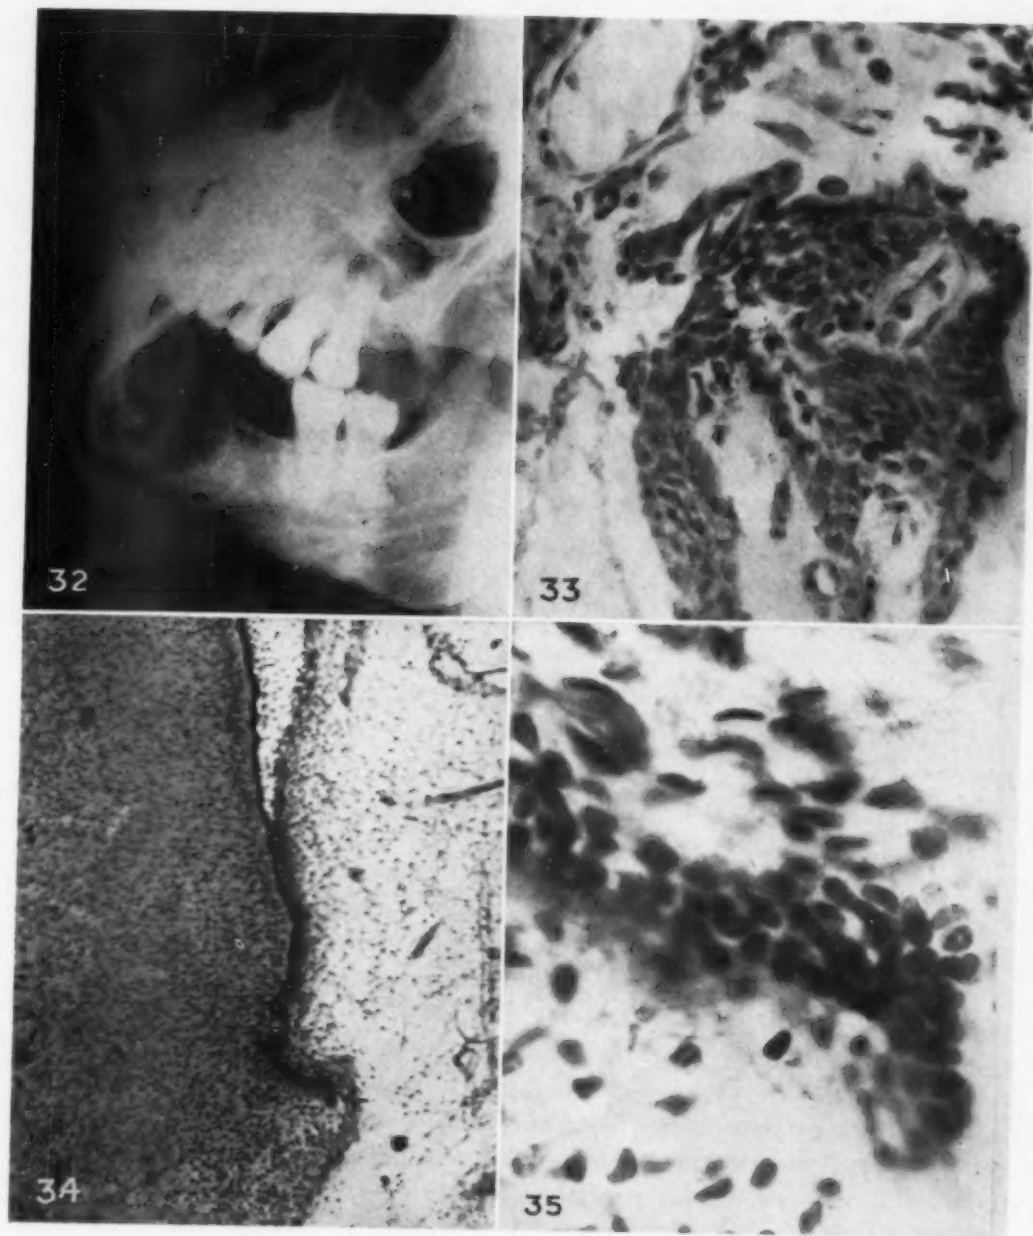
Case 10. Radiograph of right mandible showing circumscribed radiolucent area produced by cystic tumor.
